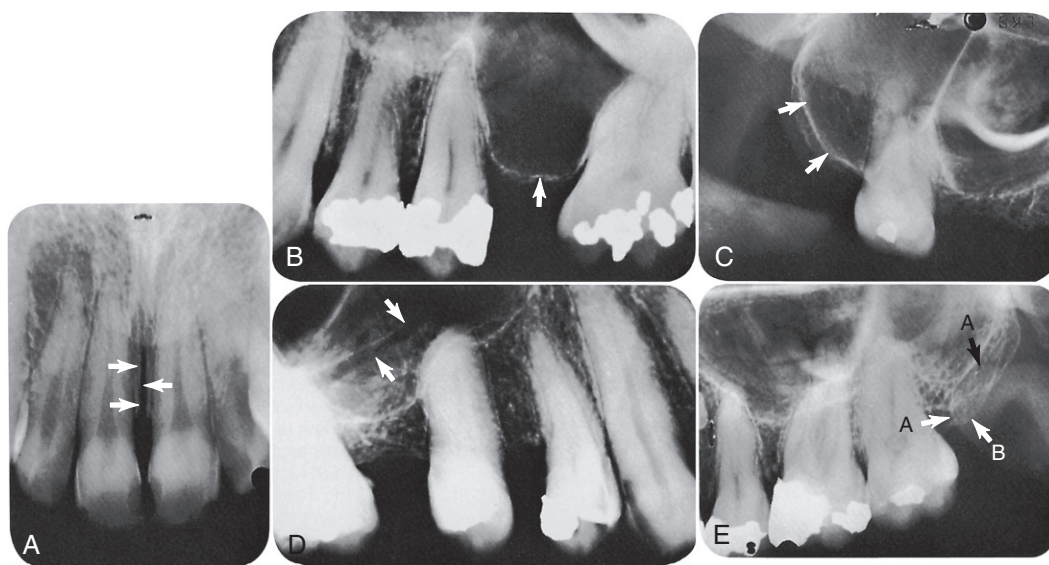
II A, Radiograph of the medial palatine suture, the appearance of which might be interpreted as a fracture. Radiographs visualize various extensions of the maxillary sinus. B, Alveolar extension. C, Tuberosity extension. D, Radiograph in which the canal for a superior alveolar artery is seen. E, Radiograph showing typical superimposition of the coronoid process: A, of the mandible on the tuberosity; B, of the maxilla.
